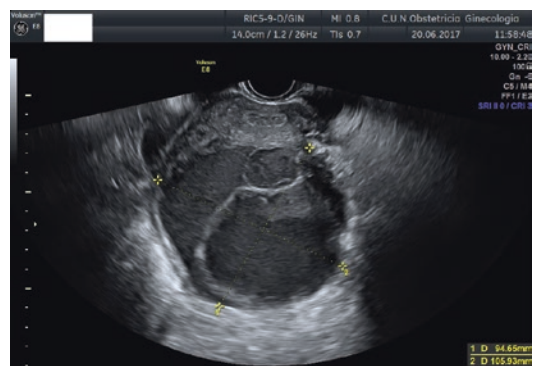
Transvaginal ultrasound showing a “multilocular” endometrioma. Actually, this finding used to be several endometriomas one adjacent to each other
